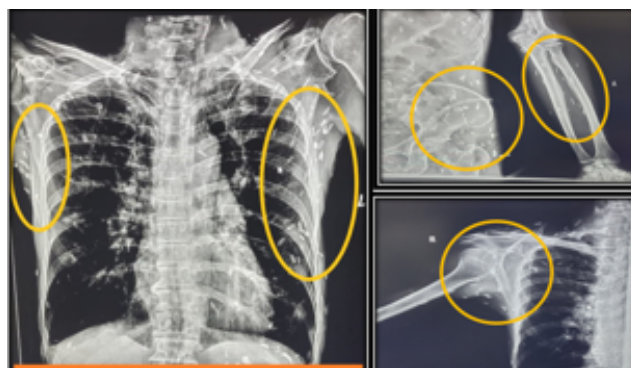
Chest radiograph suggestive of calcific specks giving a characteristic appearance of “rice-grain calcifications”
